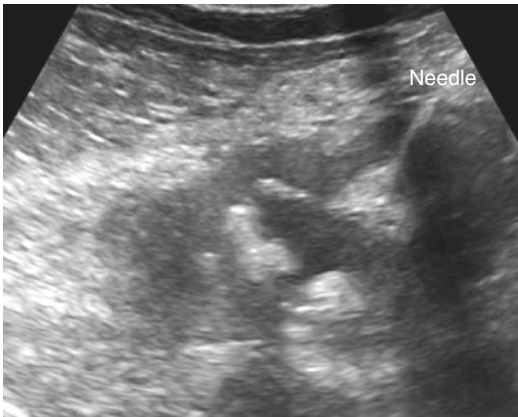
Ultrasound image of needle entry into target calyx
